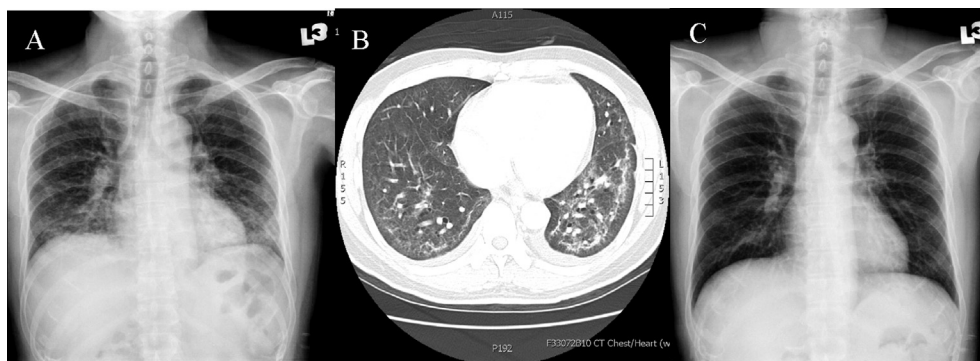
(A) Chest radiograph shows bilateral interstitial infiltration of lung fields. (B) Computed tomography scan exhibits bilateral diffuse ground-glass picture. (C) Follow-up chest X-ray shows improvement after caspofungin complete therapy.
